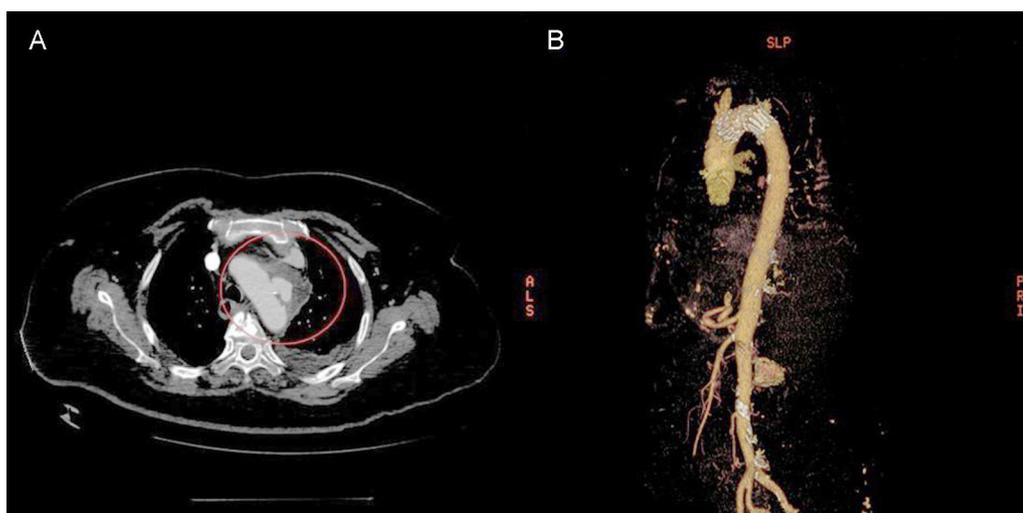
A, Computed tomography contrast scan showing an infected inflammatory aneurysm measuring 24×15 mm in the aortic arch. B, Three-dimensional reconstruction showing endovascular repair following the insertion of a thoracic stent graft.
